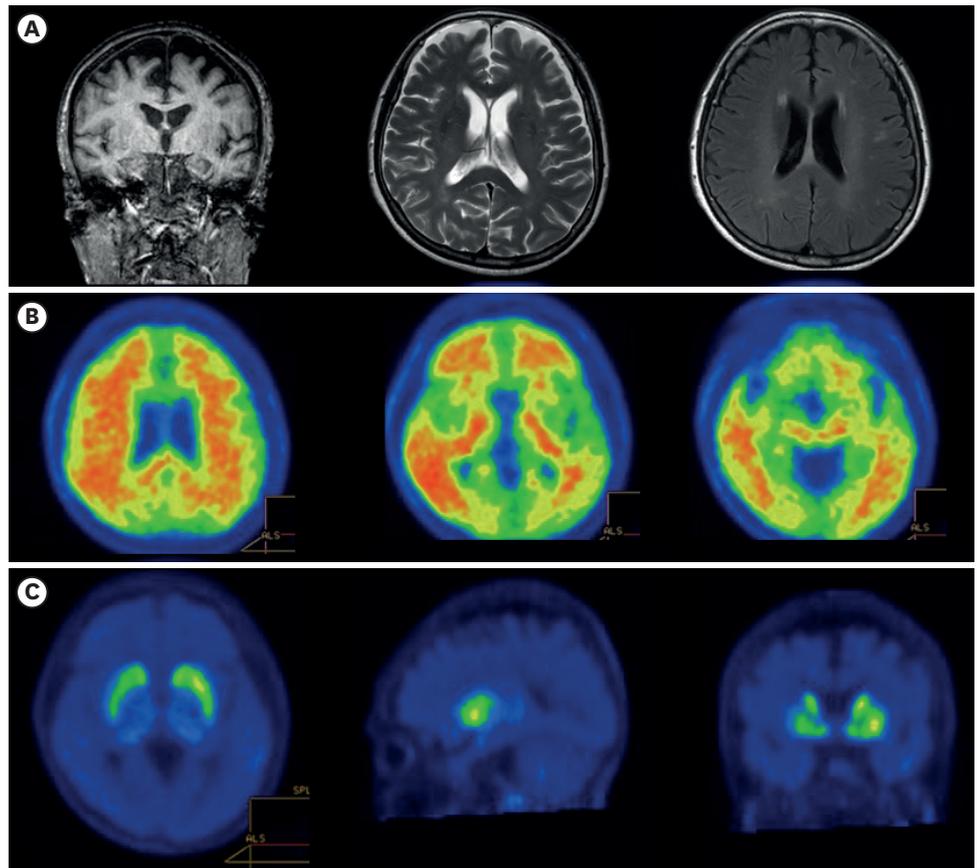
Neuroimaging of Patient 2. Brain magnetic resonance imaging showed (A) left temporal atrophy, hippocampal atrophy score of 0 on the right and 1 on the left based on the Scheltens' scale¹¹ and grade 0 periventricular and grade 1 deep white matter hyperintensities based on the Fazekas scale.¹² F-18 Flutemetamol positron emission tomography computed tomography showed (B) abnormal extensive accumulation of β -amyloid plaque in the brain, including the frontal, temporoparietal cortex, and striatum. Subsequent 18F FP-CIT positron emission tomography showed (C) abnormal decreased FP-CIT uptakes in both basal ganglia on delayed phase.
